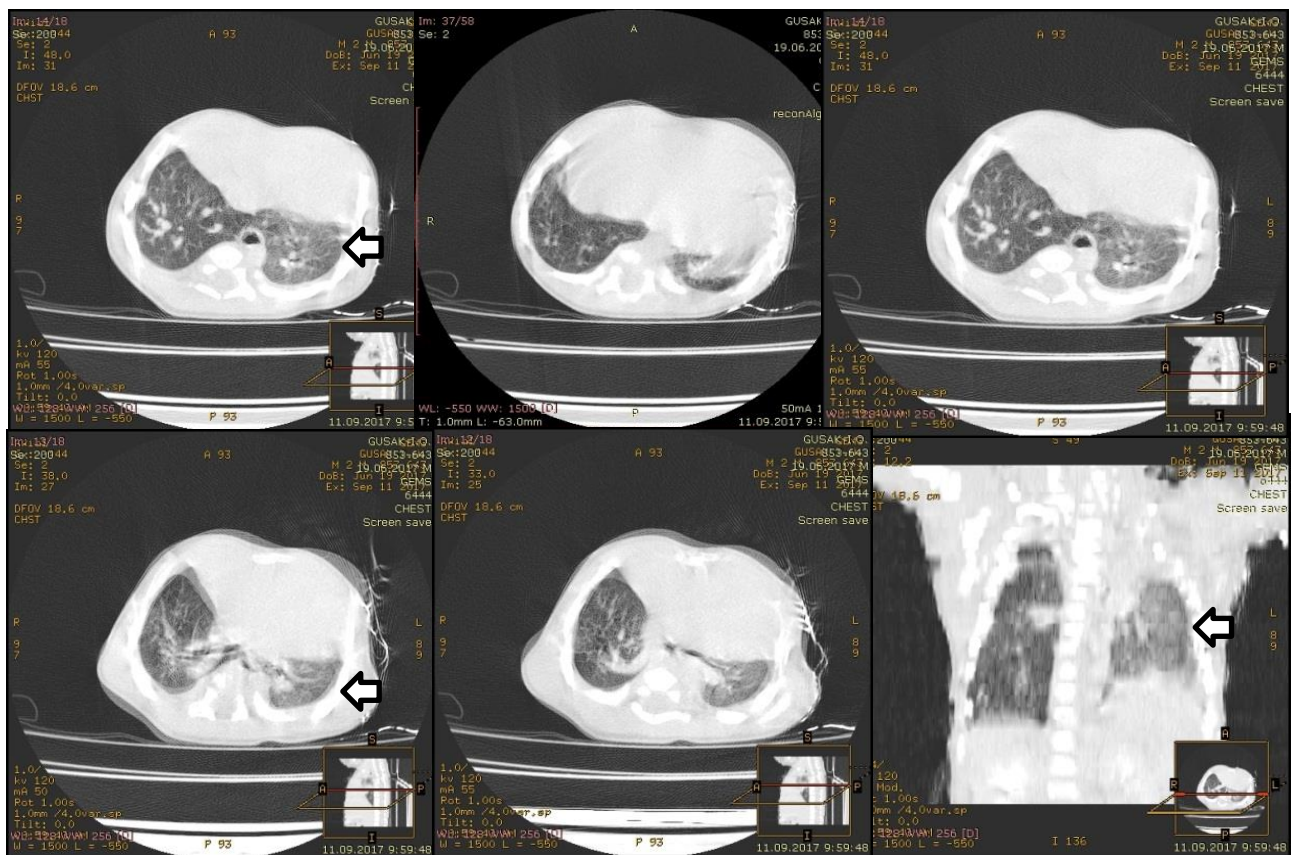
A 3-months-old male patient. High resolution computed tomography of chest organs (spiral pitch of 1 mm) with contrast: left lung lower lobe hypoplasia, cupula of the diaphragm with a relaxed left contour.
